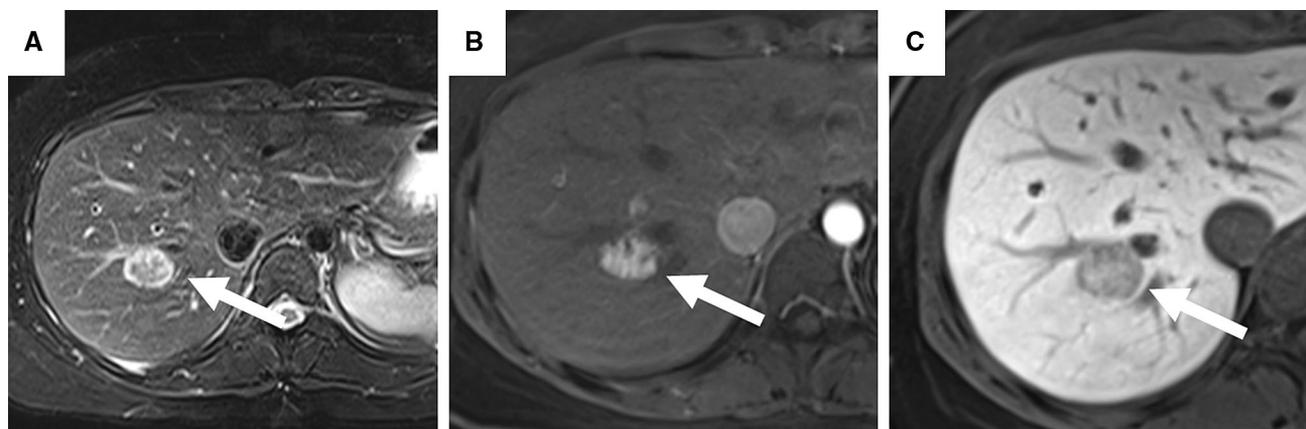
Contrast-enhanced MRI with gadoxetic acid (Primovist) performed on a 30-year-old female patient with no risk factors for HCC development showed a mass in segment 7 of the liver (arrowed). The mass showed intense T2 hyperintensity (A). Note that the mass showed intense, heterogeneous arterial enhancement (B) and washout
